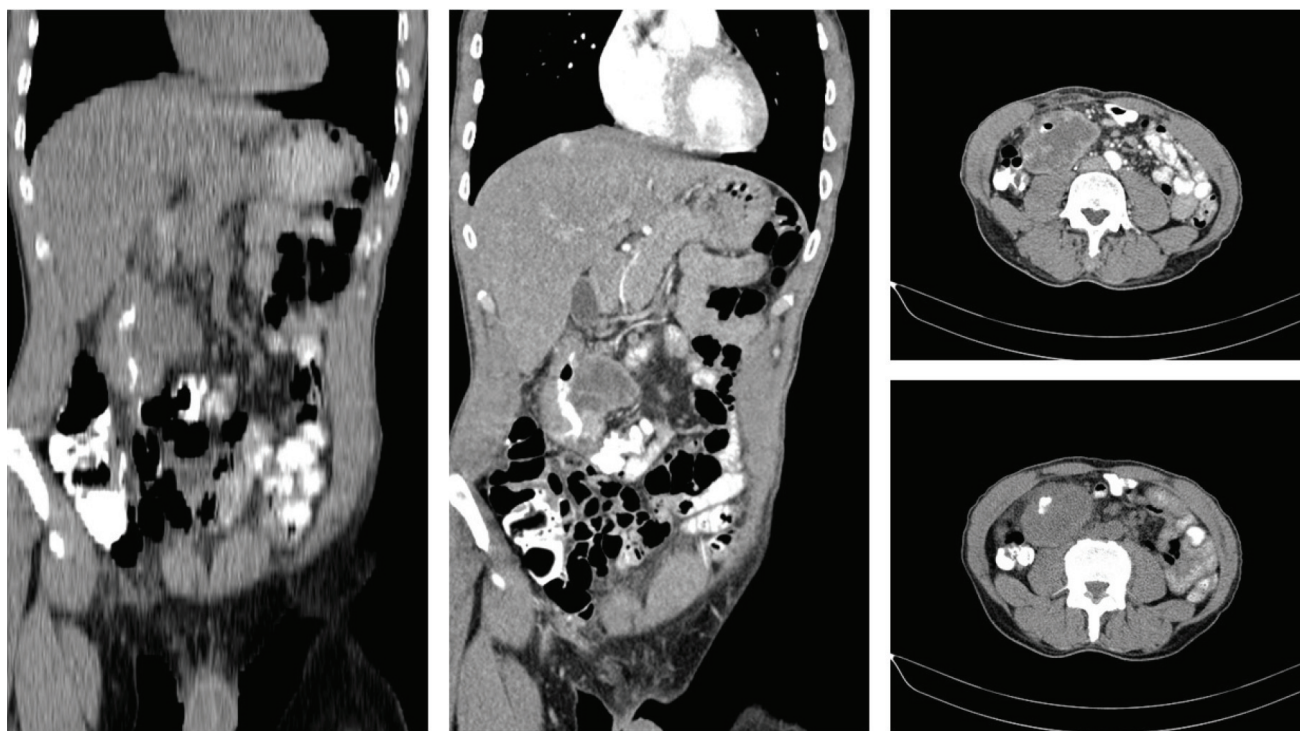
Sagittal and coronal sections of a post-contrast CT scan of the abdomen and pelvis showing a well-defined long segment of irregular circumferential wall thickening associated with significant luminal narrowing is seen involving the hepatic flexure as well as the related upper third of the ascending colon. It is associated with large extra-luminal exophytic heterogeneously enhanced mass extending posteromedial abutting related right psoas muscle.
